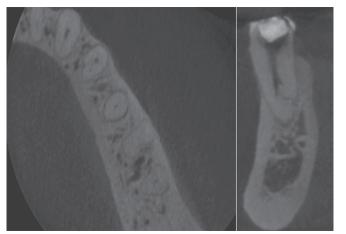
Cone-beam computed tomography shows root morphology (Case 1)
